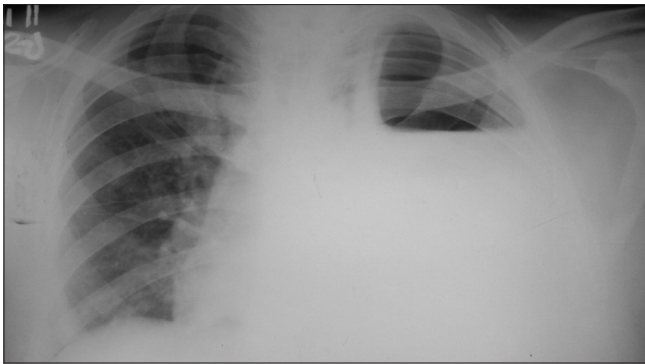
Chest radiograph showing left-sided hydropneumothorax
